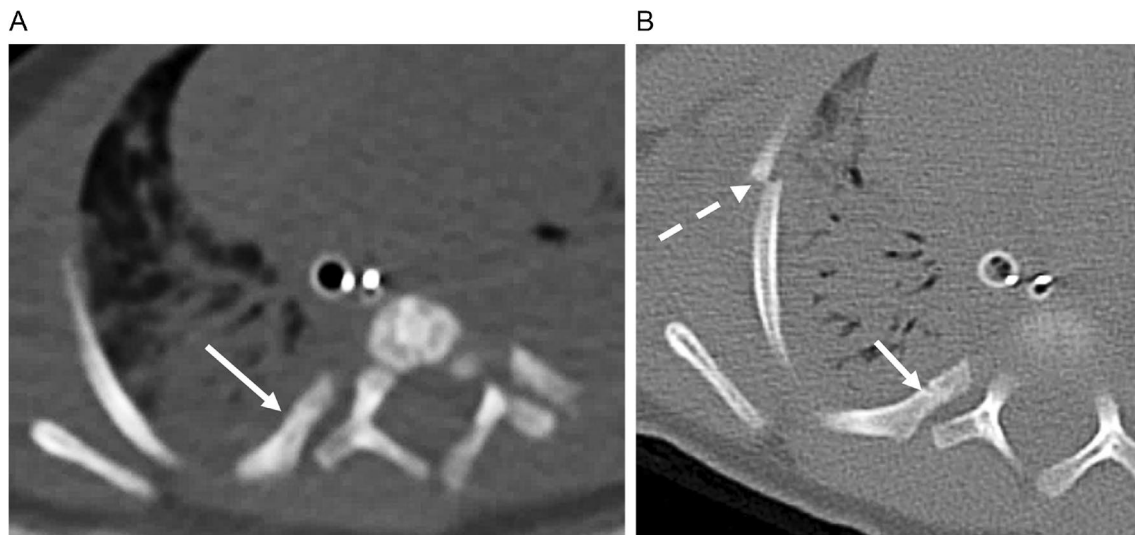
A 2-month-old boy who was a victim of physical abuse. a An axial antemortem computed tomography (CT) scan performed with low-dose technique, 80 kVp beam energy, and a tube current of 190 mA with a pitch of 0.8, a 200-mm field of view (FOV), and a soft tissue kernel has poor resolution for bone assessment. A posterior rib fracture is obscured (*arrow*). b An axial image from the postmortem
